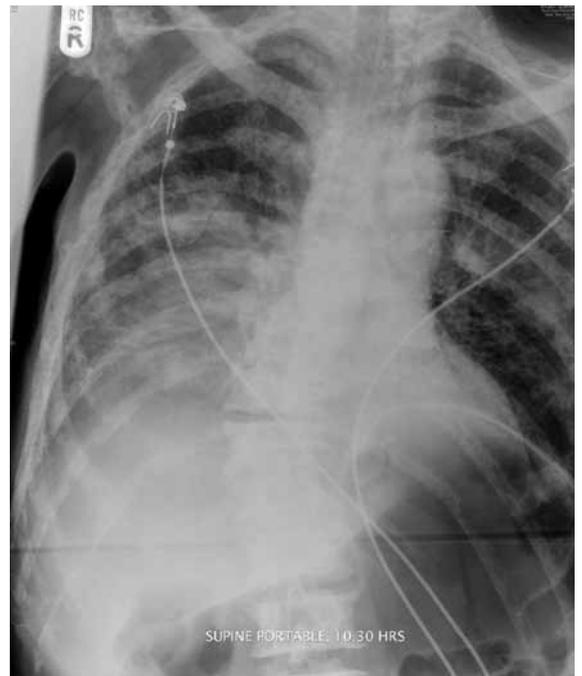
Chest Xray of patient 2 after tracheal intubation
